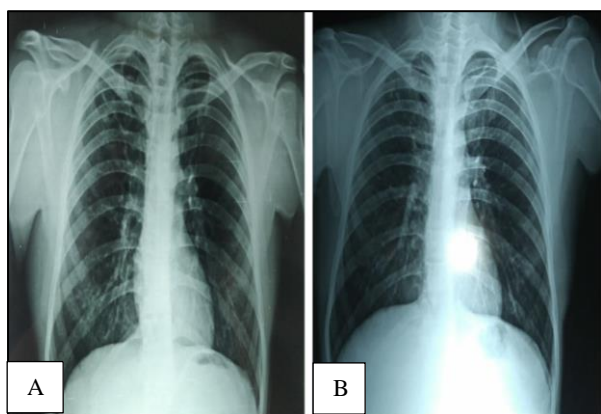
(A) Pre-treatment chest X-ray; and (B) chest X-ray taken after 6 months of treatment.
